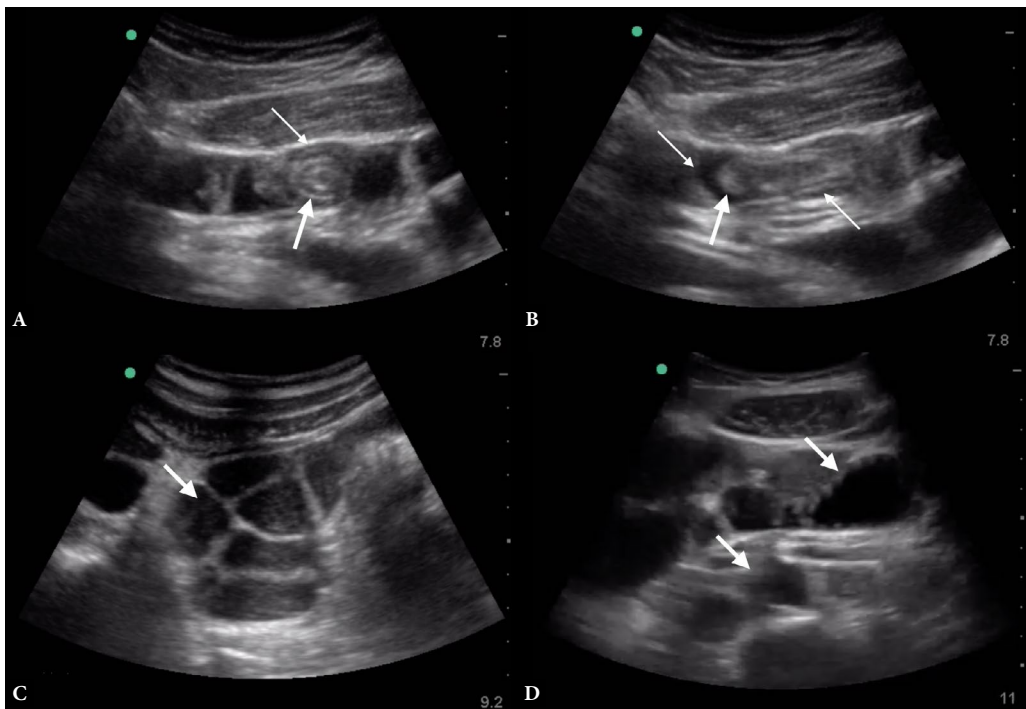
A. Ileo-ileal intussusception in transverse and B. longitudinal view with outer intussusciens (thin arrow) and central intussusceptum (thick arrow). C, D. Mildly dilated bowel loops with very early sonographic ileus (arrows)
